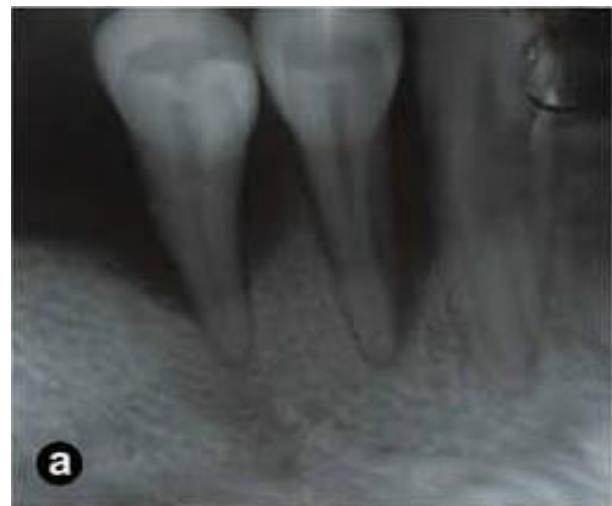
Case B. X-Ray images before treatment (a) and six months after (b)
